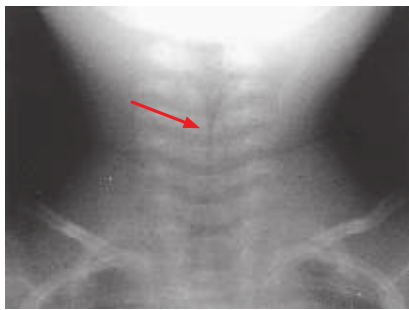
Croup. Anteroposterior x-ray of the neck in this 1-year-old child with inspiratory stridor and cough shows the classic “steeple sign” (arrow) consistent with the subglottic narrowing of laryngotracheobronchitis. (Reproduced with permission from Stone CK, Humphries RL. *Current Diagnosis & Treatment: Emergency Medicine*, 6th ed. New York, NY: McGraw-Hill; 2008.)
